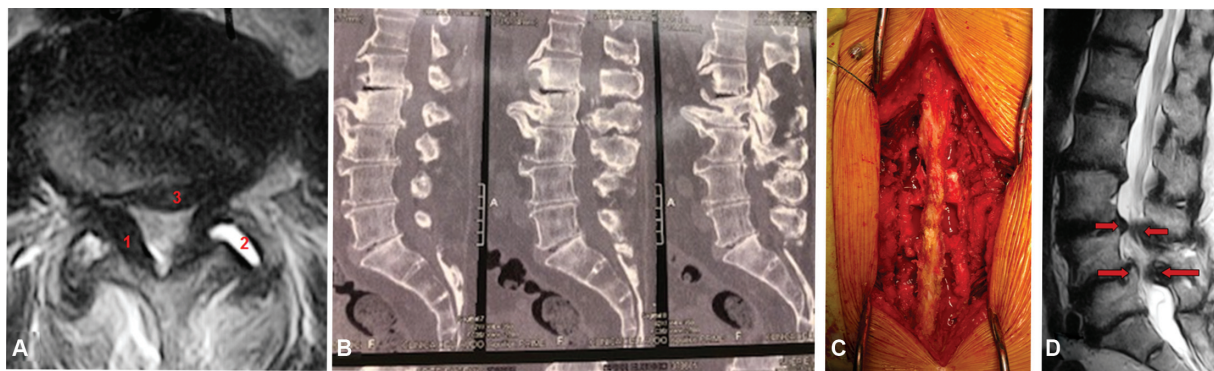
(A) Axial magnetic resonance imaging (MRI) showing spinal stenosis with ligamentum flavum thickening (1), facet arthrosis with synovitis (2) and disc protrusion (3). (B) Sagittal computed tomography (CT) scan showing L1-L2-L3-L4 spinal stenosis. (C) Surgical photography: three-level decompression using the conventional laminectomy technique plus lateral recess resection and bilateral foraminotomy. (D) Sagittal MRI showing degenerative L3-L4 and L4-L5 stenosis with degenerative spondylolisthesis in L4-L5.
